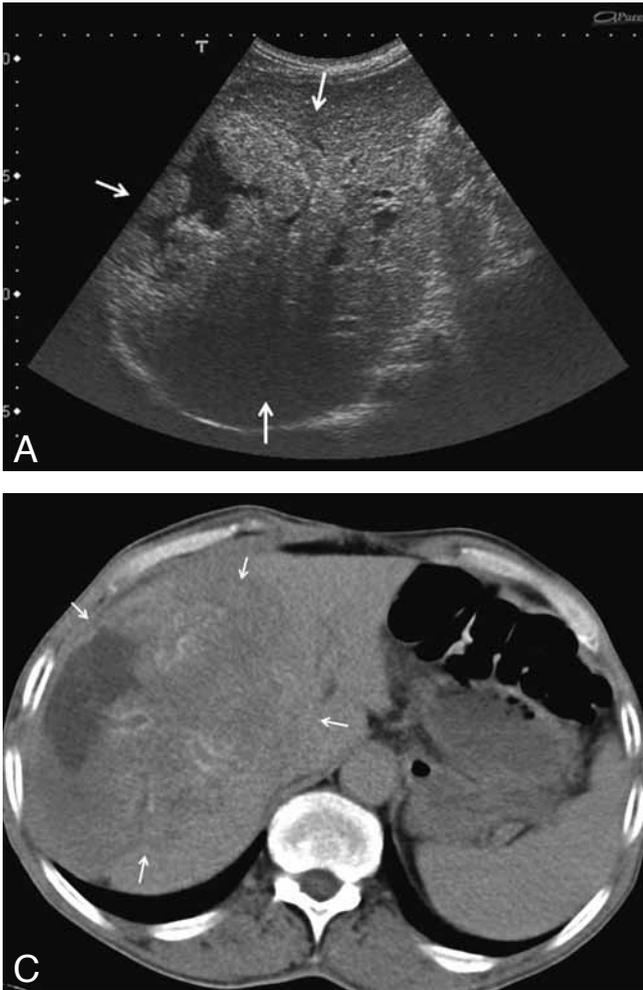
A: Axial grey-scale ultrasound image reveals a large hepatic mass with heterogenous echogeneity. B: On unenhanced CT image the mass shows heterogeneous hypodensity and contains calcific areas. C: After intravenous administration of the iodinated contrast material, the mass does not show any enhancement.
